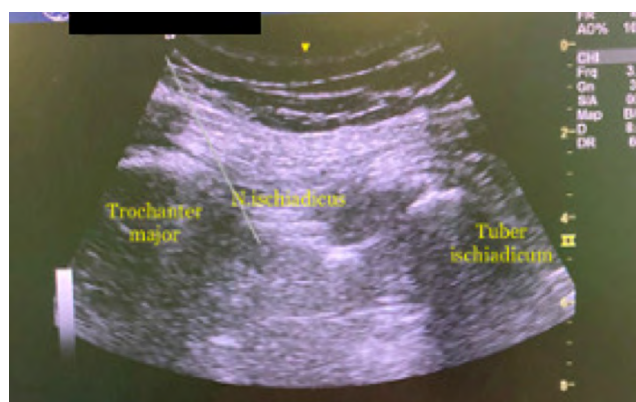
Ultrasound image of the sciatic nerve and surrounding tissues.
